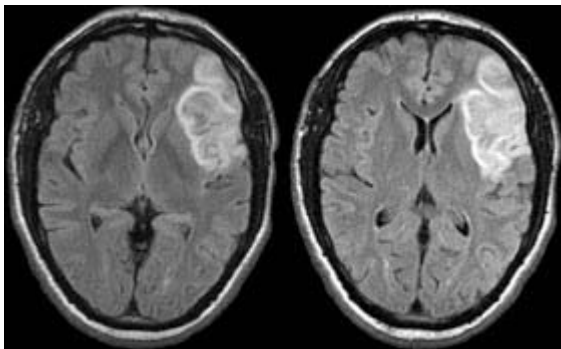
MR imaging showing MCA superior territory infarct.
